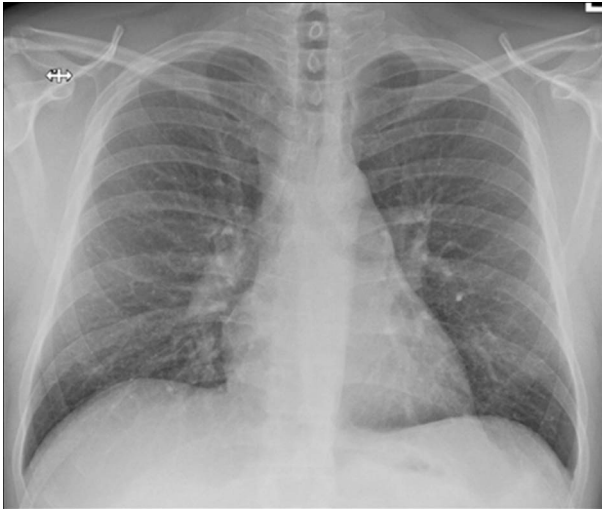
Chest radiograph following discontinuation of sertraline and commencement of oral dexamethasone. Marked reduction in bilateral pulmonary infiltrates compared with admission radiograph visible.
